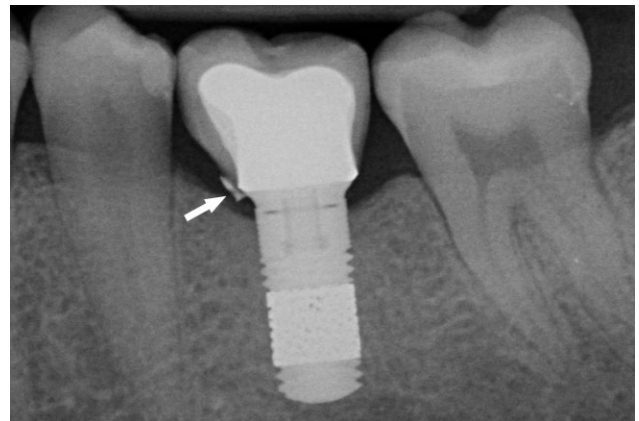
Postoperative (2 weeks): radiographic view of the definitive restoration in place. Note the cement fragment (arrow), which was subsequently removed.
